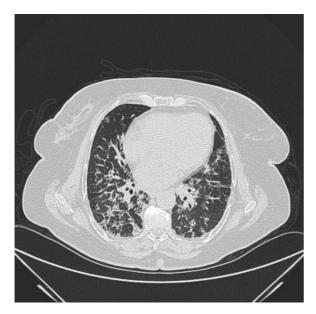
Computed tomographic scan of the chest in a patient with cryptogenic organizing pneumonia (typical pattern) demonstrating bilateral alveolar opacities (with peripheral predominance).
